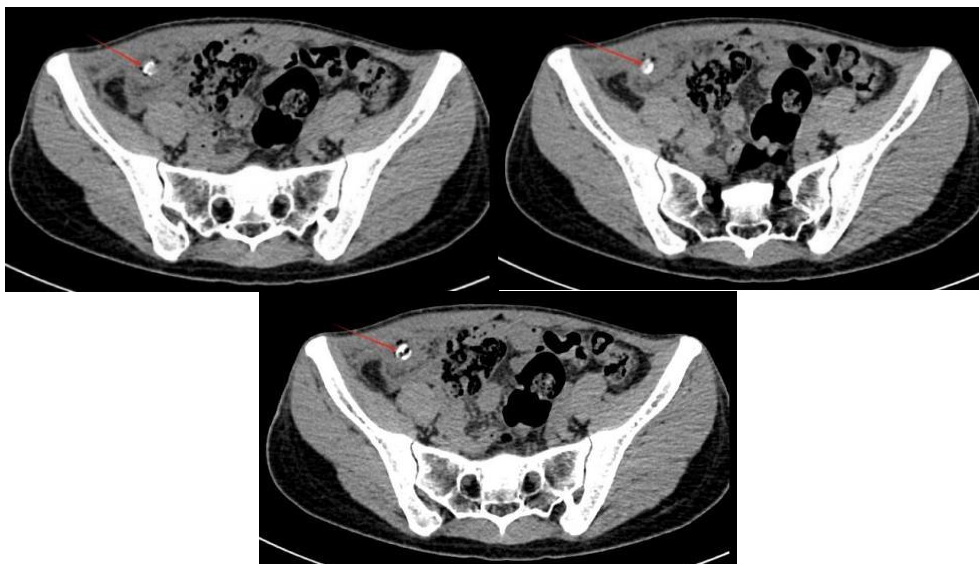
CT Examination after LA showed that the enlarged appendix shadow found in the original lower right abdomen has disappeared, and the flaky high-density shadow can still be observed on the right side of the pelvic cavity (the position pointed by the arrow).
